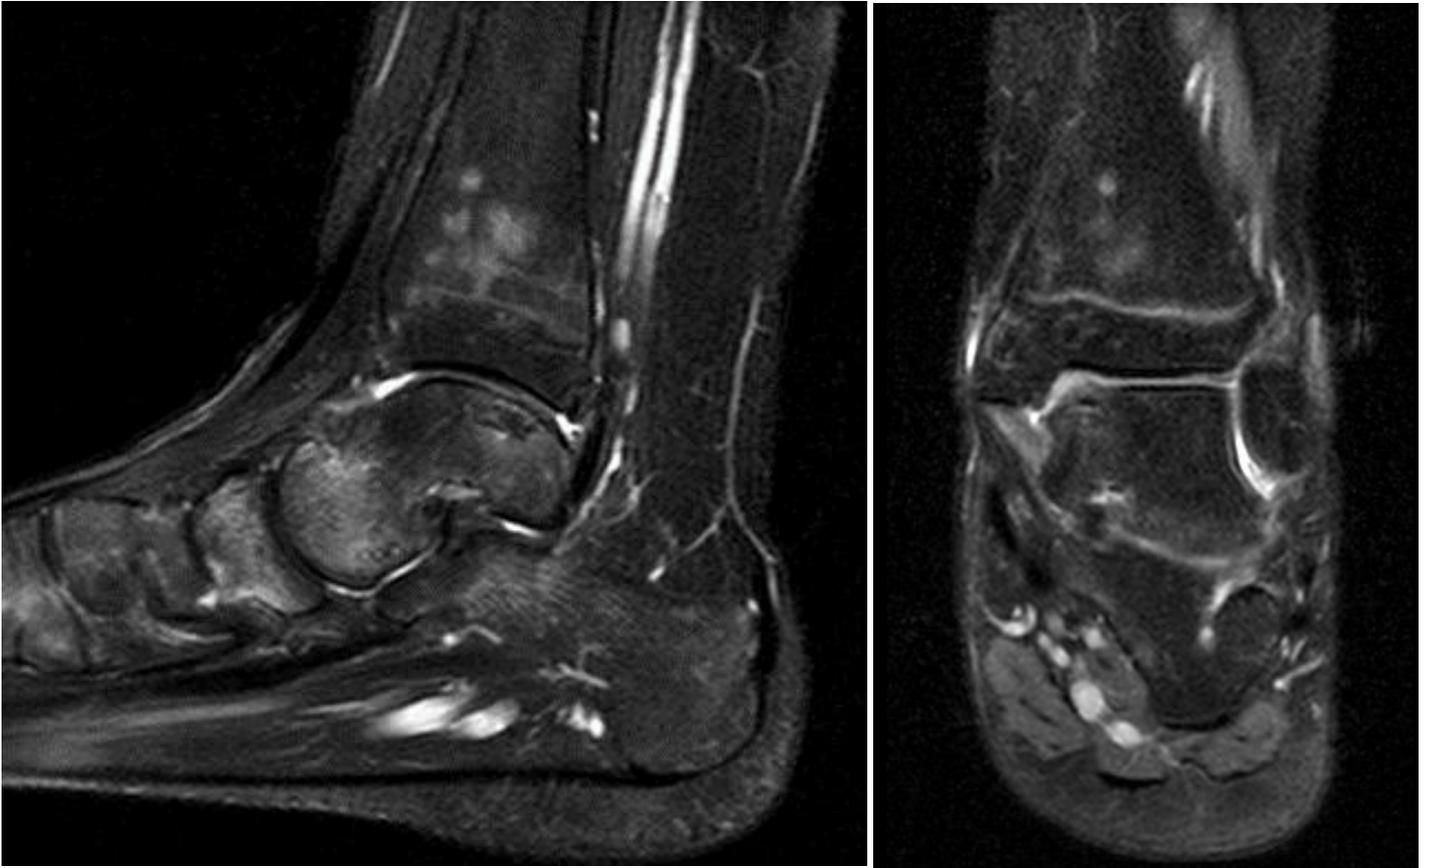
post-operative 6-month MRI demonstrating near complete healing of surgically treated OCD and resolution of bone marrow edema.
